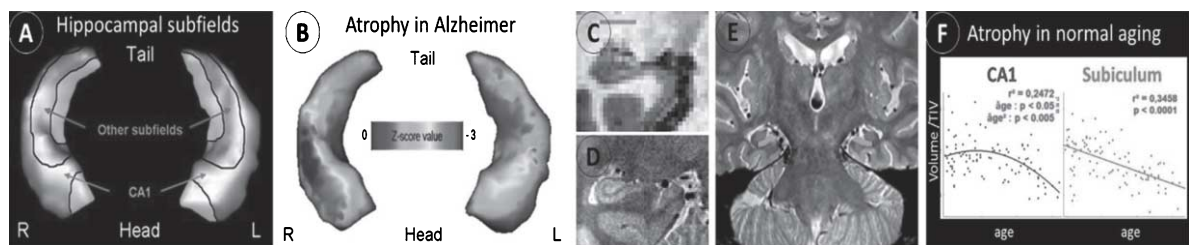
Differential alteration of hippocampal subfields in AD versus normal aging. The hippocampal subfields can be distinguished on 3D hippocampal surface views (A), and this technique showed predominant atrophy of the CA1 subfield in AD (B). Compared to standard resolution T1 MRI (C), a high-resolution proton density MRI sequence allows to visualize the hippocampus fine anatomy (D) and thus to delineate the different hippocampal subfields (E). This approach is promising for early AD diagnosis as it allows to distinguish the effects of AD from that of other conditions such as normal aging (F).
